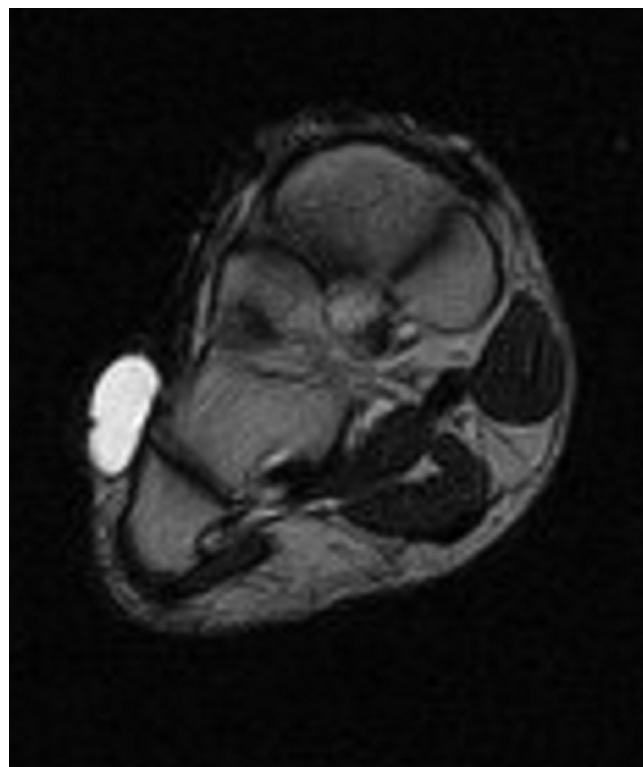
Axial views of MRI scan demonstrating a ganglion of the dorsum of foot.
